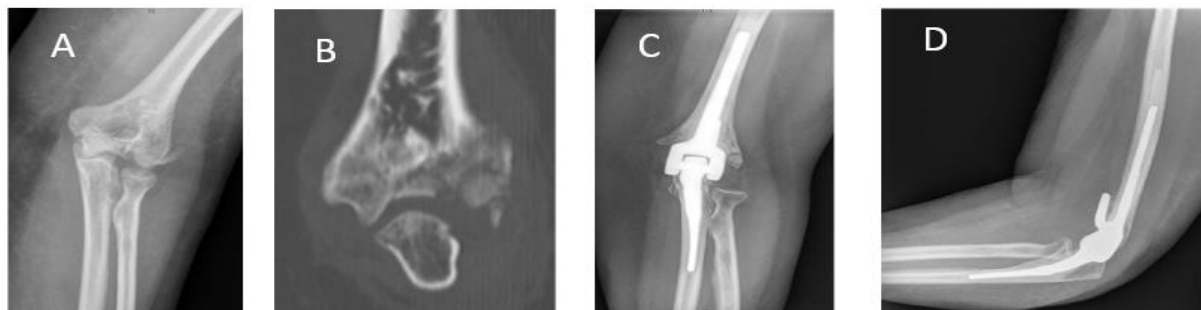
69-year-old female with a comminuted, displaced, distal humerus fracture. Due to the fracture pattern, reconstruction was deemed impossible during surgery, and therefore patient underwent total elbow arthroplasty (TEA): (A-B) preoperative views; (C-D) postoperative radiographs
